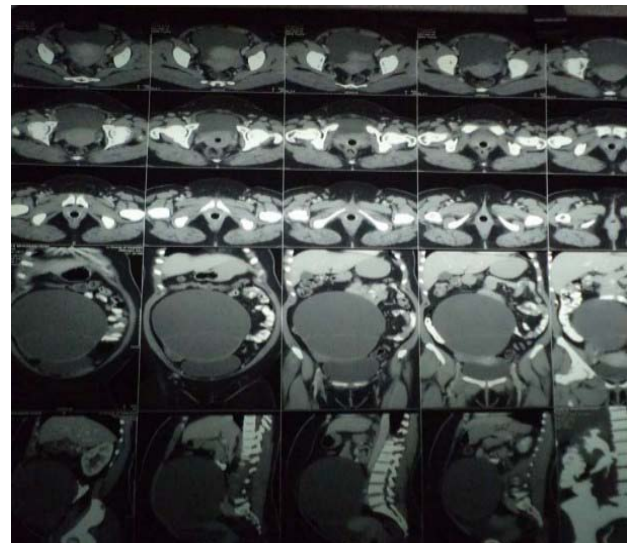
CT image of a benign serous cyst adenoma
